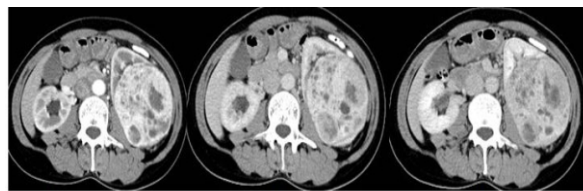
A 49-yr female patient. Triphasic CT shows a large CCC in the left kidney with marked and heterogeneous enhancement and clear rim and necrosis.
